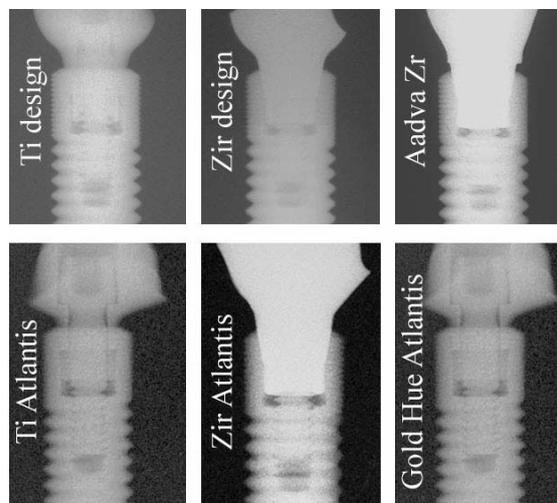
From left, radiographic adaptation of Ti-design, Zir-design and Aadva Zr abutments.
